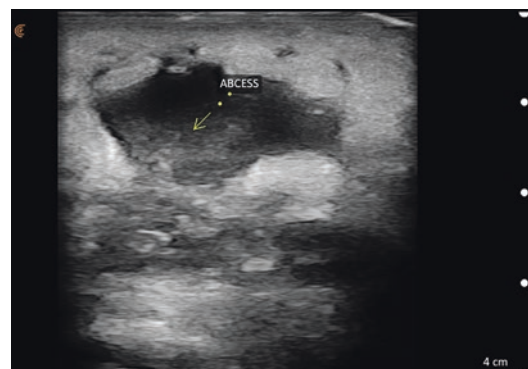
Grayscale ultrasound image of medial knee showing an abscess. The hyperechoic edematous soft tissue surrounds a mostly anechoic chamber with internal debris echoes
